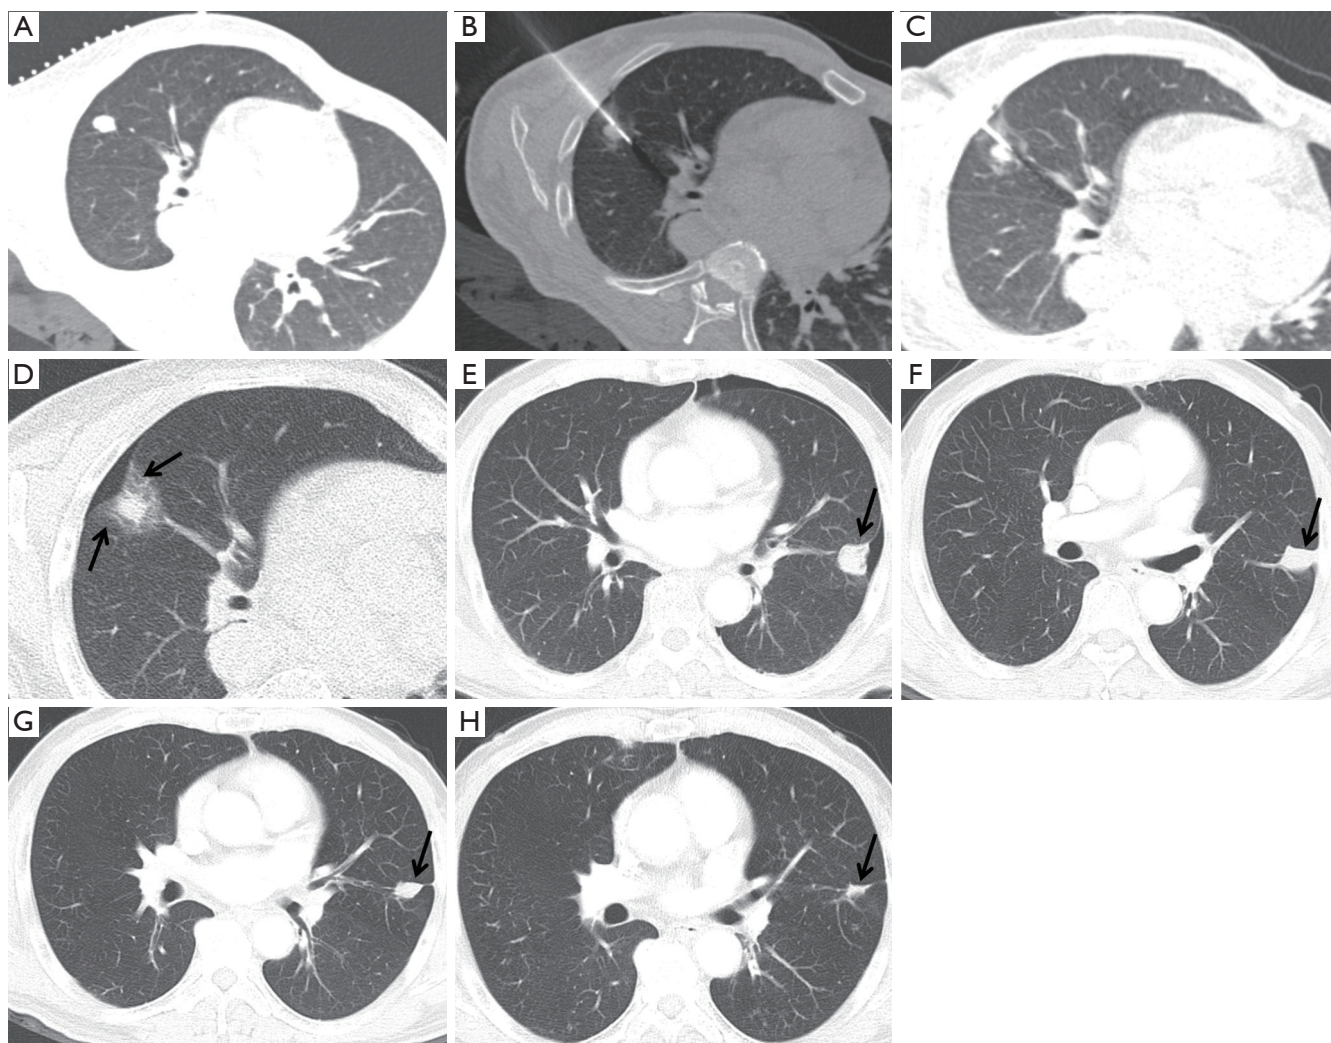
Successful RFA for solitary pulmonary metastasis in a 61-year-old male patient with hepatocellular carcinoma. (A) CT scan obtained before RFA showing a 1.4 cm × 1.0 cm metastatic nodule in the left upper lobe; (B,C) CT scan obtained during RFA. Metastasis was treated using three overlapping ablations; (D) CT scan obtained immediately after RFA showing a 2.9 cm × 3.0 cm ablation zone (arrows); (E-H) follow-up CT scans obtained 1 month (E), 3 months (F), 6 months (G), and 12 months (H) after RFA showing gradual constriction of the ablation zone (arrows) and no evidence of local recurrence. RFA, radiofrequency ablation
